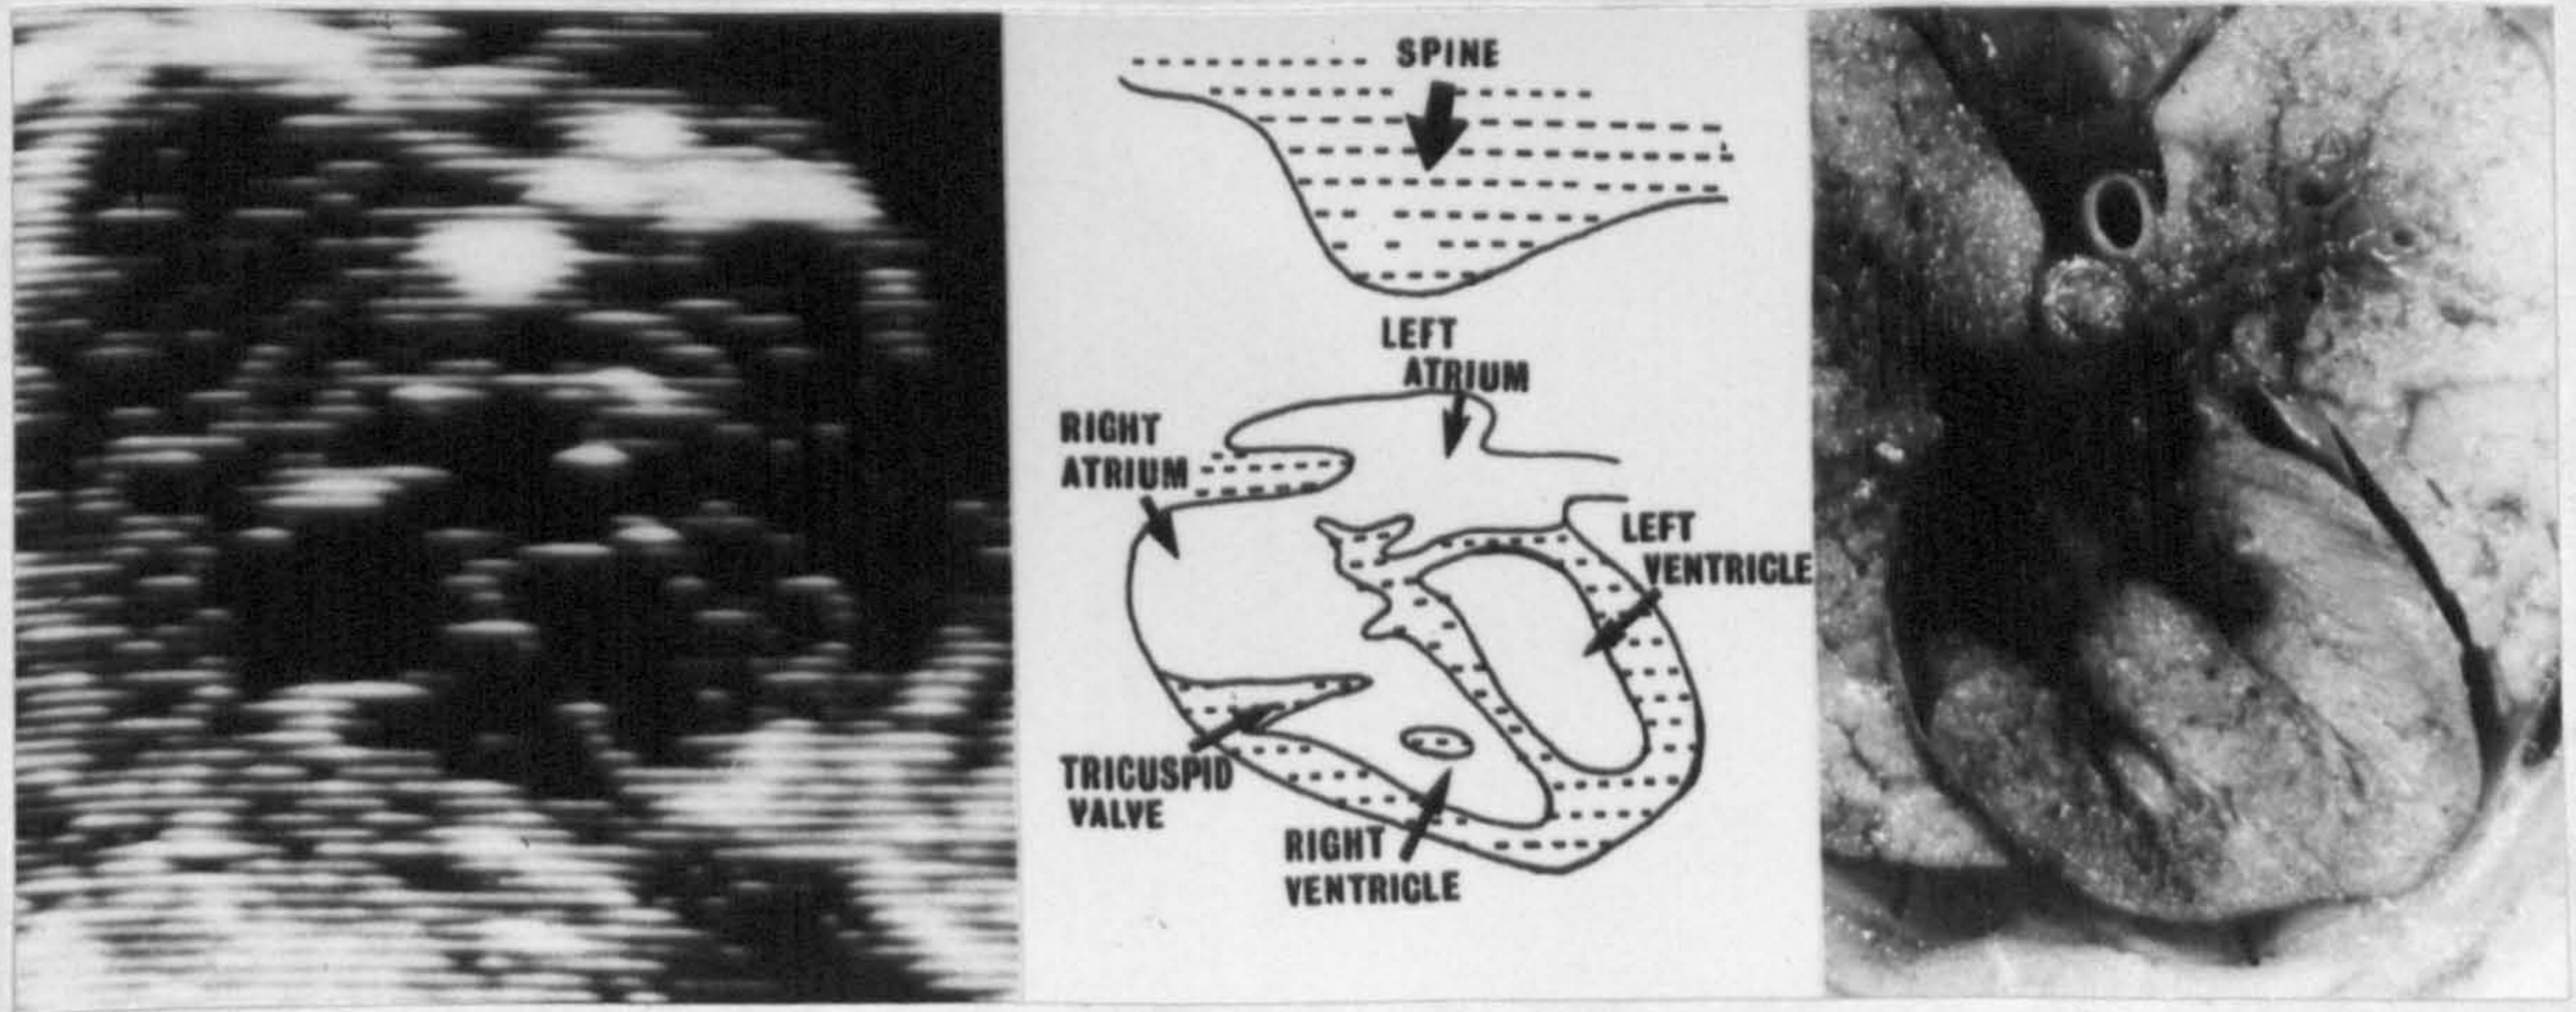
The fetal heart is seen echocardiographically and anatomically in the four chamber projection. The two atria and intra-atrial septum are seen. The right and left ventricle and intra-ventricular septum are seen. The mitral and tricuspid valves are seen.
